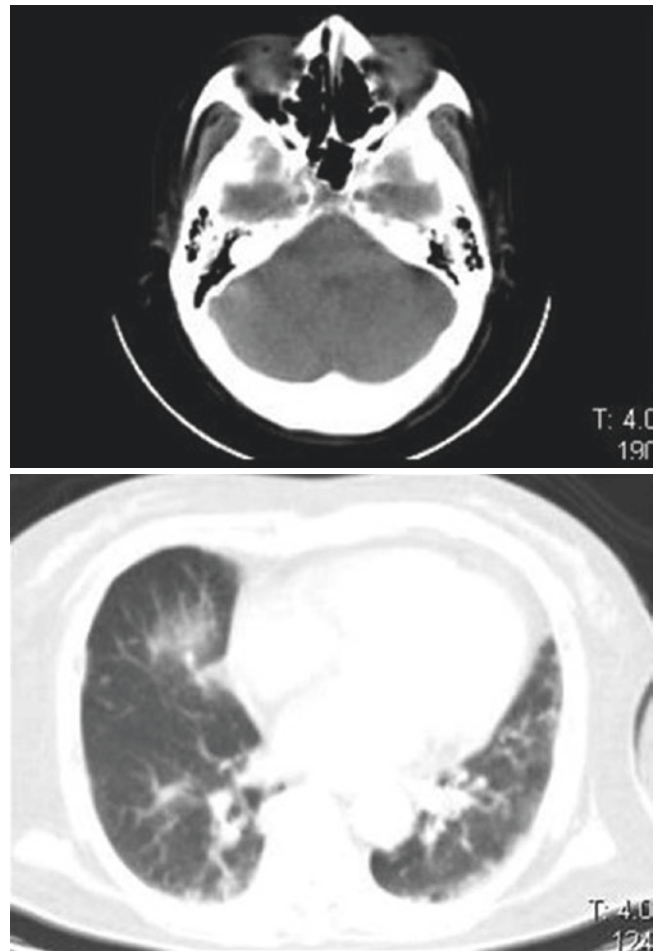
Nonenhanced CT alone did not show the nasal lesion in this figure
